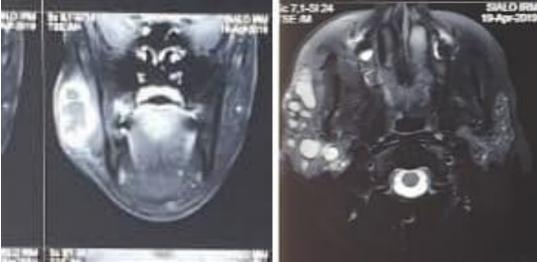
Cervical MRI in coronal (right) and axial (left)
